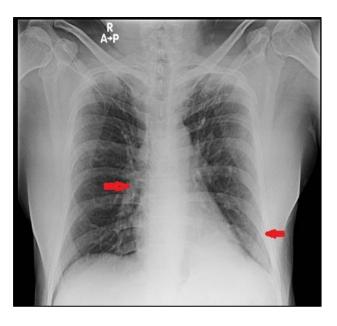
Chest X-ray of bilateral infiltrates.
